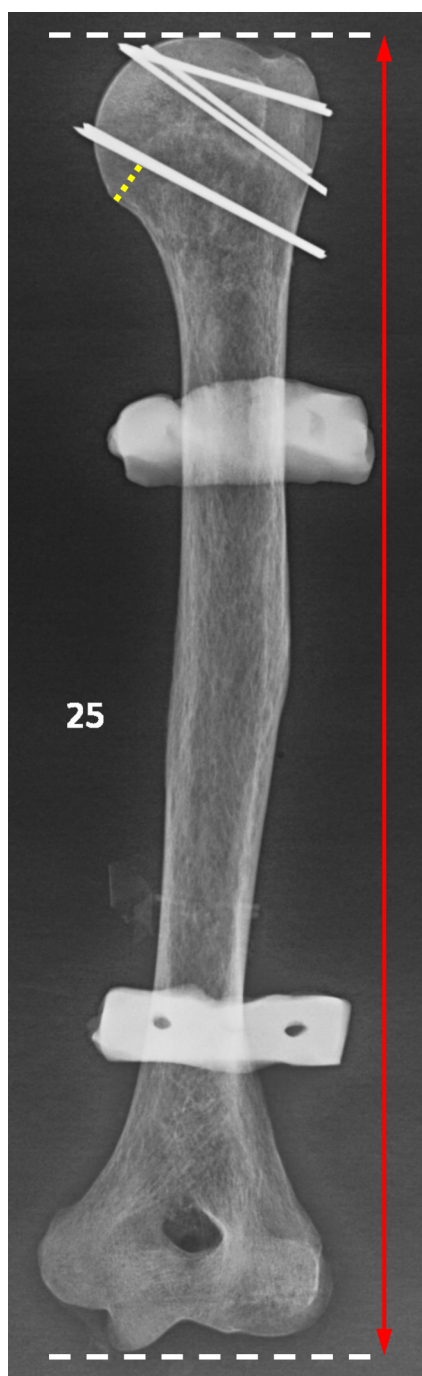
Radiographic measurement depicting total humeral length (red line) and the distance from the calcar to the most inferior Kirschner wire (yellow line).
